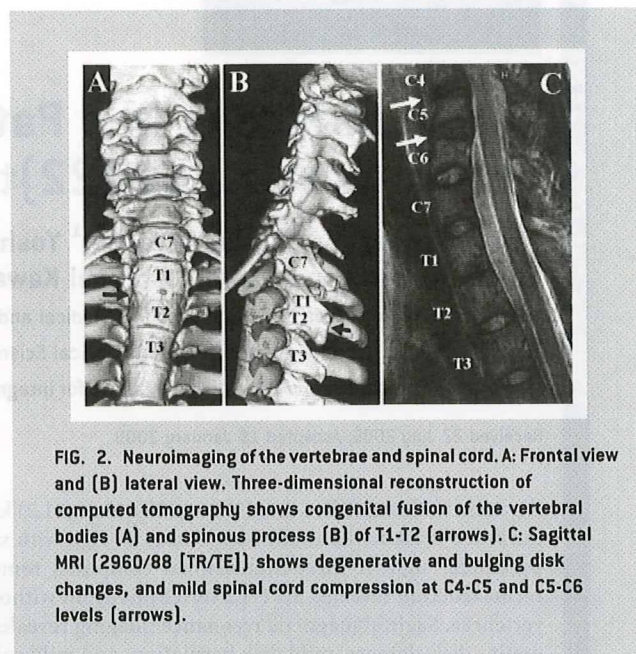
Neuroimaging of the vertebrae and spinal cord. A: Frontal view and (B) lateral view. Three-dimensional reconstruction of computed tomography shows congenital fusion of the vertebral bodies (A) and spinous process (B) of T1-T2 [arrows]. C: Sagittal MRI [2960/88 [TR/TE]] shows degenerative and bulging disk changes, and mild spinal cord compression at C4-C5 and C5-C6 levels [arrows].
